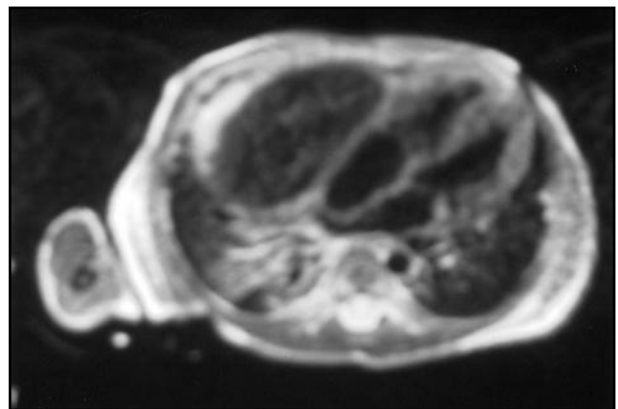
MRI chest showing the liver adjacent to the heart
